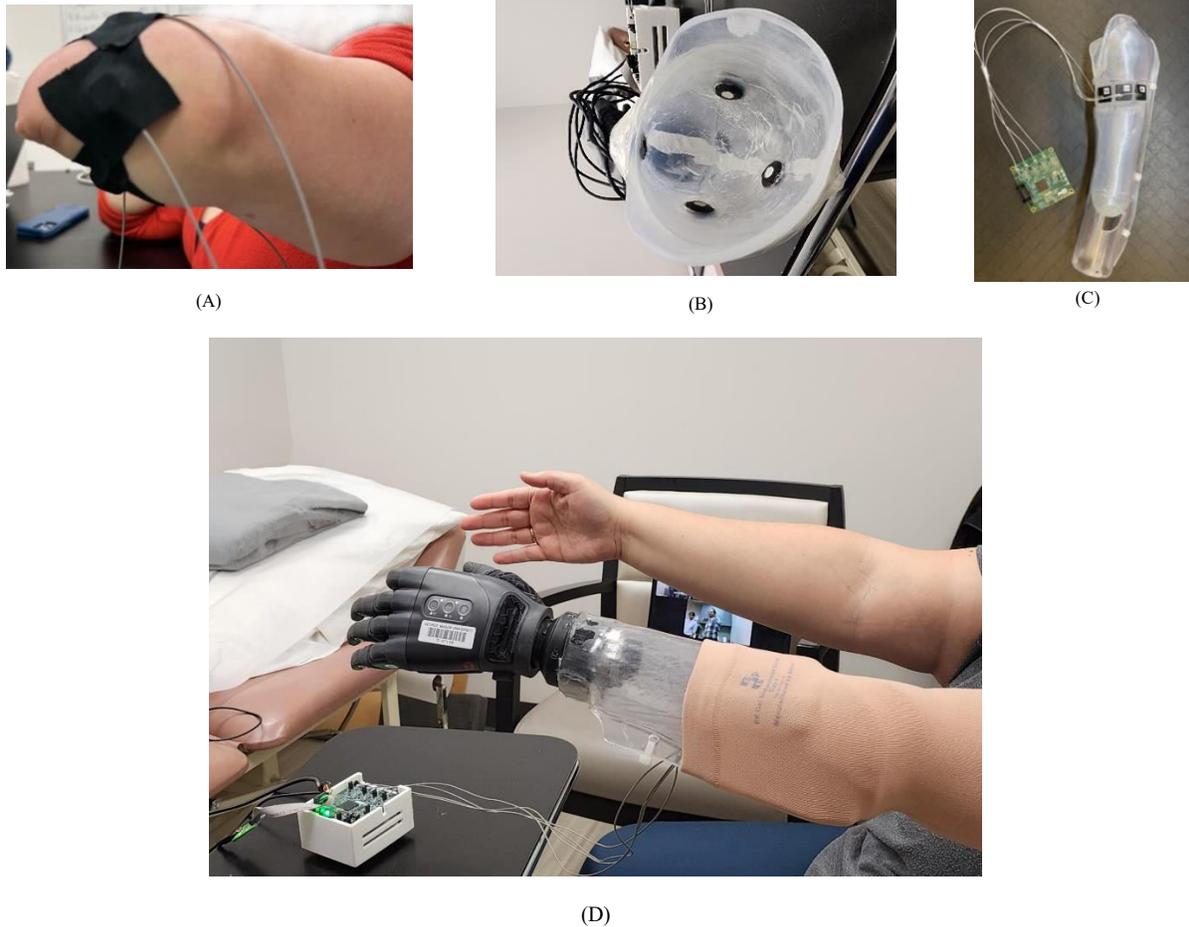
(A) SMG sensor location (B) Custom-fitted socket integrated SMG sensors for the second participant, (C) Custom-fitted socket integrated SMG sensors for the first participant, attached to our custom designed prototype ultrasound front end electronics circuit board, and (D) Our participant wearing the prosthetic socket with TASKA hand
